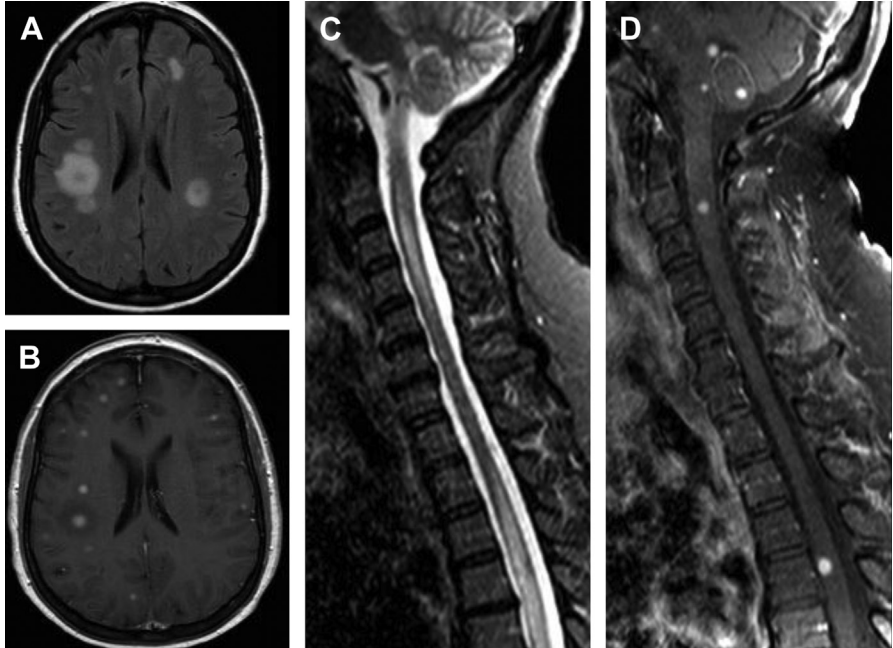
Histoplasma encephalomyelitis* in the setting of prior rituximab and methotrexate use. (A) Axial T2-FLAIR (fluid-attenuated inversion recovery) brain MRI, (B) axial T1 postcontrast brain MRI, (C) midsagittal T2 MRI of the spine, (D) axial T1 postcontrast MRI of the spine.
